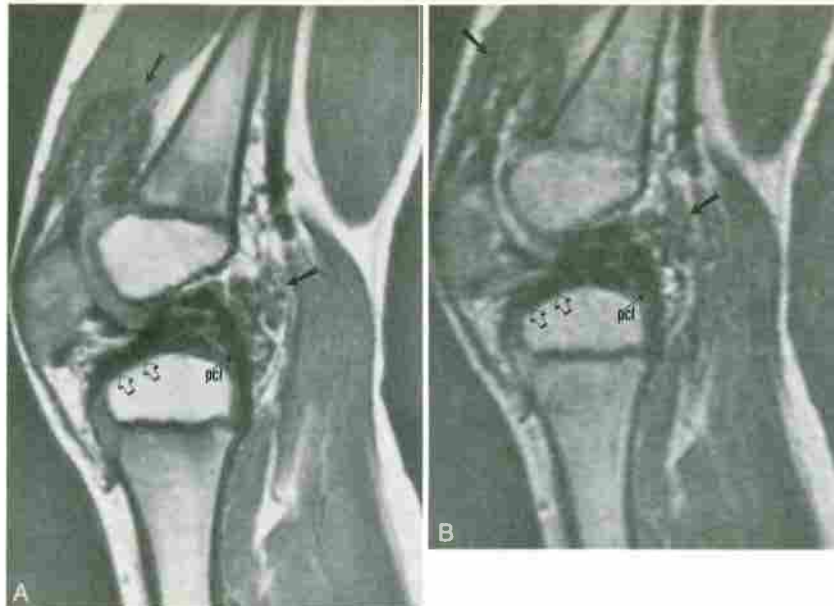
Hemophilic arthropathy. Five-year-old patient with known hemophilia and a swollen right knee. A, T1-weighted (TR/TE, 600/25) and (B) corresponding T2-weighted (TR/TE, 2000/80) sagittal images demonstrate low-signal-intensity pannus (arrows) in suprapatellar pouch and surrounding the posterior cruciate ligament (pcl). The low signal intensity of the pannus is a reflection of the hemosiderin content. Note that the pannus has eroded the tibial cartilage anteriorly (open arrows). MR depiction of cartilage destruction eliminates synovectomy as a therapeutic option for this patient.
